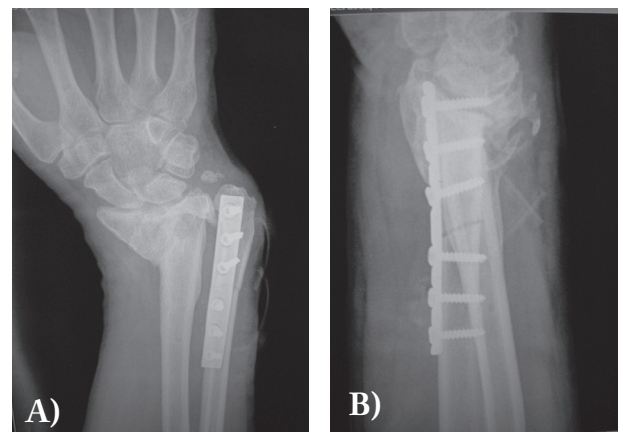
(Case 1). A) AP view X-ray post ulnar shortening; B) LL view X-ray post ulna shortening
